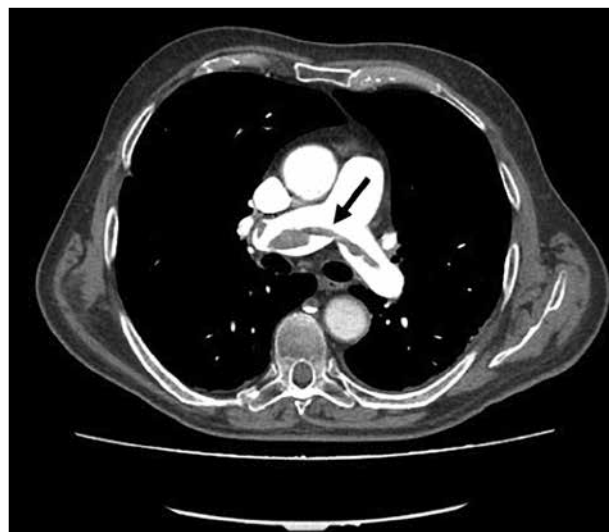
Computed tomography pulmonary angiography (CTPA) demonstrating saddle pulmonary embolism partially obstructing both main pulmonary arteries; the white area above the center is the pulmonary artery, opacified by radiocontrast; the black arrow indicates the pulmonary thrombus.
